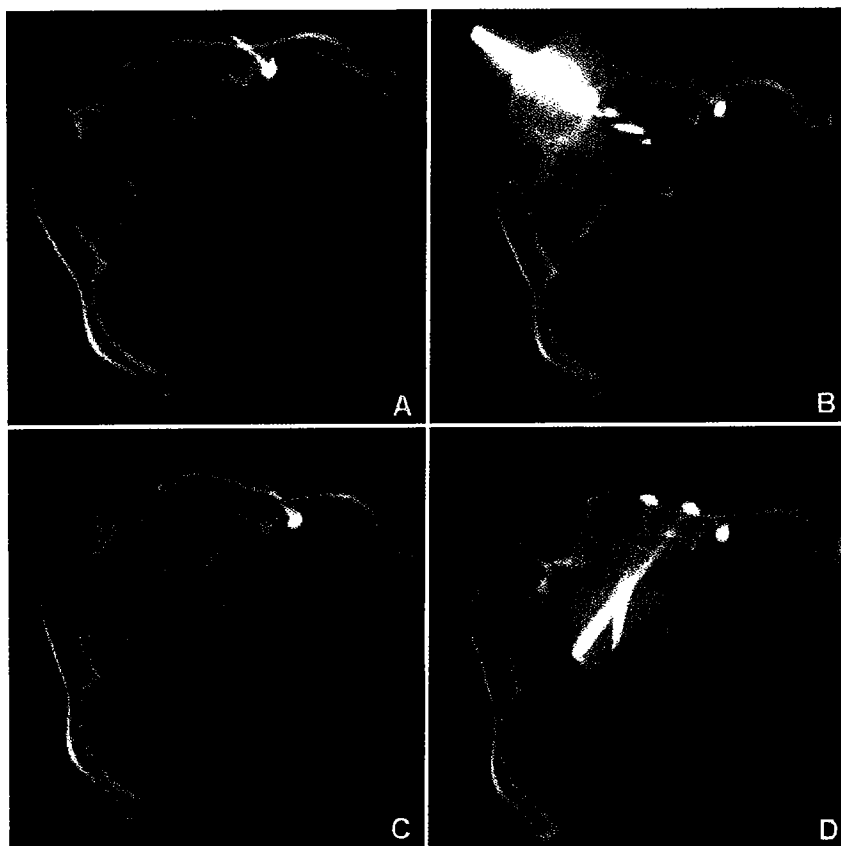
A Intraoperative planning CT demonstrating the delayed union of the sacrum. B CT-navigated drilling of the delayed union with a 10 mm cannulated trephine over an initially placed 2.8 mm guidepin. Note exact delineation of the drill position in regard to the anterior sacral cortex and the sacral foramina. C Intraoperative control after filling of the reamed area with autologous cancellous bone from the iliac crest over a sterile single use proctoscope. CT demonstrates complete filling of the gap from near to far cortex without endangering the presacral soft tissue. D CT-navigated placement of two 7.3 mm self-drilling/ self-cutting cannulated AO/ ASIF screws in S1 over previously inserted 2.8 mm guidepins. There was good compression of the fracture and no secondary dislocation.
